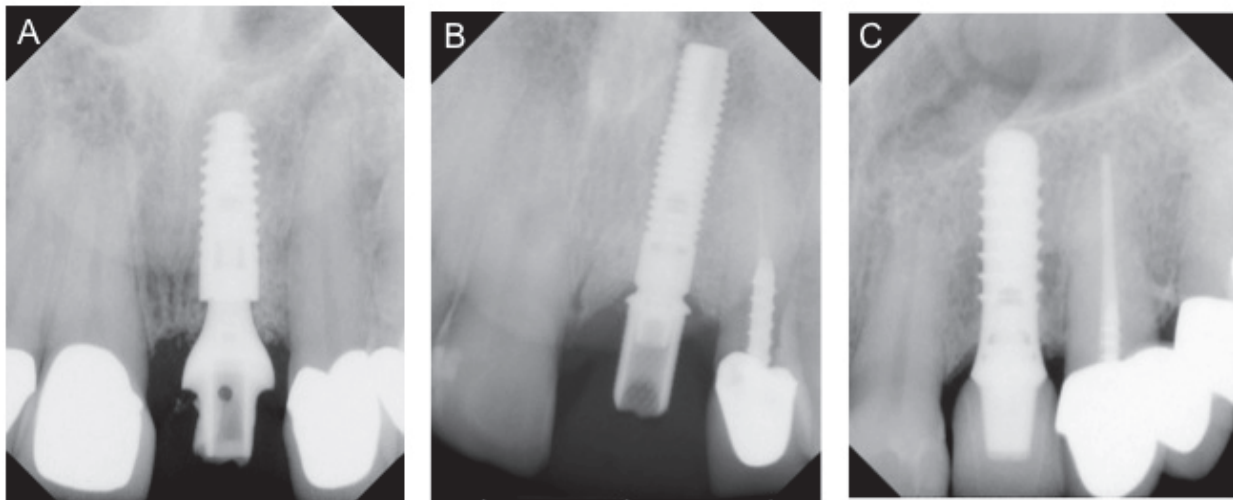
Radiographs of implants placed with the FAI at A)subcrestal, B)crestal, C)supracrestal in relation to the alveolar crest
